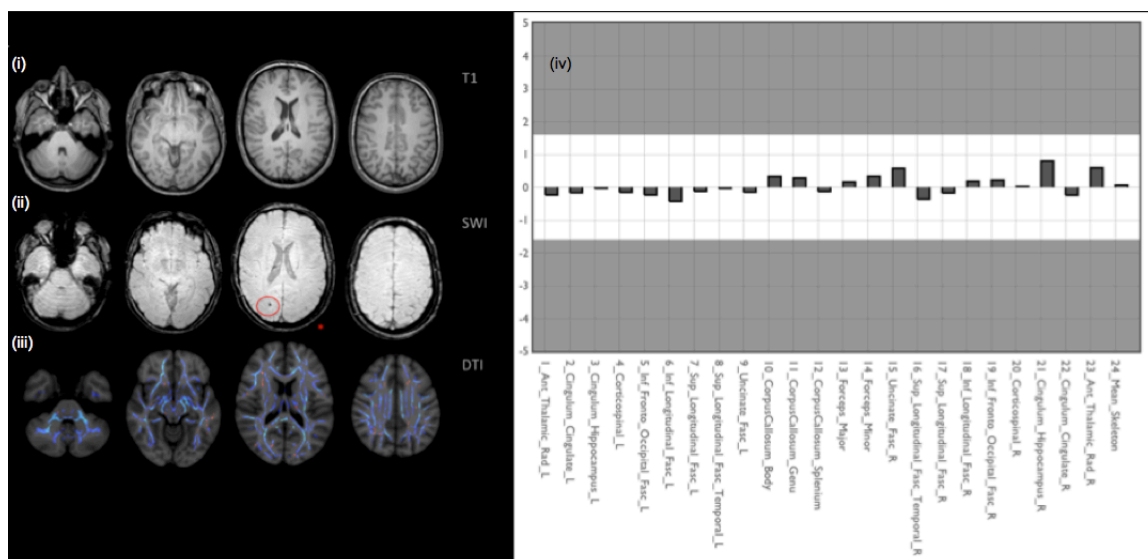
MR imaging results corresponding to Case 1
